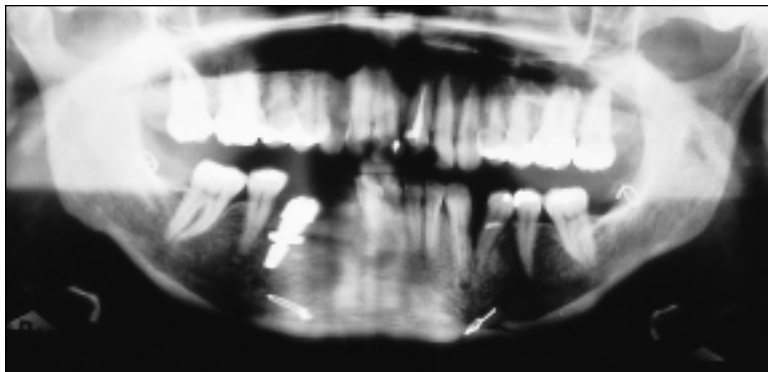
Panoramic radiograph 9 months after implant loading.
